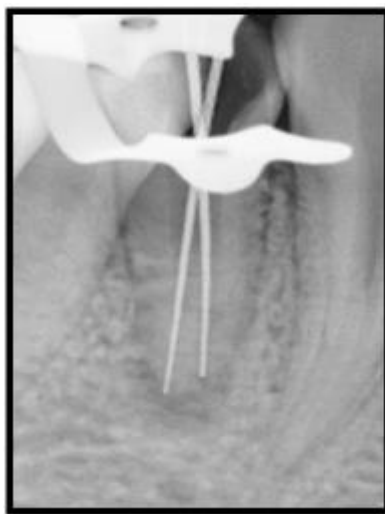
Working length radiograph showing two separate canals
